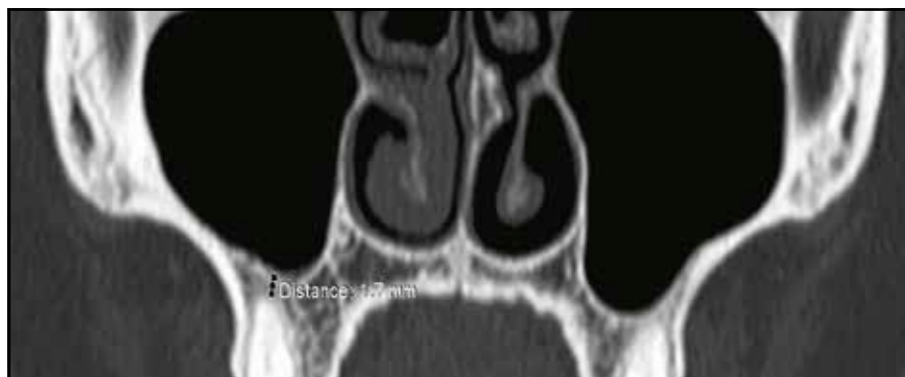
Measurement of the distance between the root apex and maxillary floor (1.7 mm) on a cranio-facial CT scan, axial slice.
